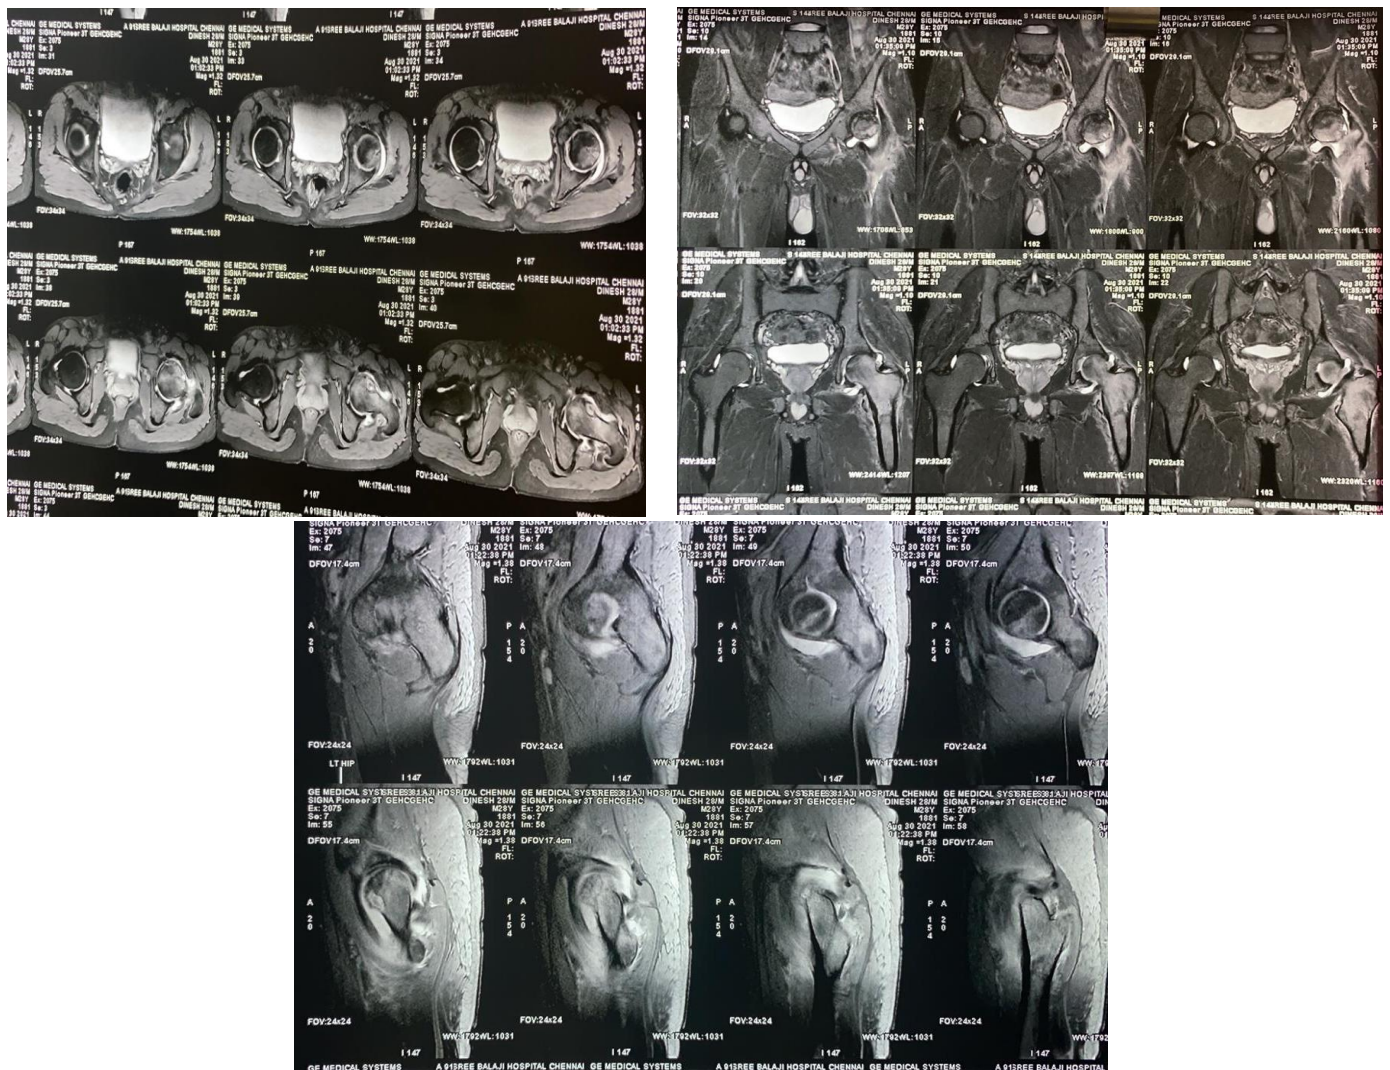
MRI-Left hip: shows grade II AVN changes
